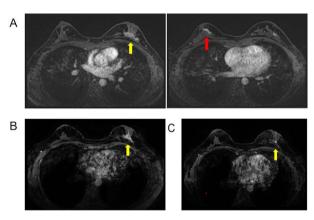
MRI findings; (A) initial breast MRI of the bilateral breast tumor; (B) tumor in the left breast after 4 cycles of taxane; (C) tumor in the left breast after the completion of NAC.
